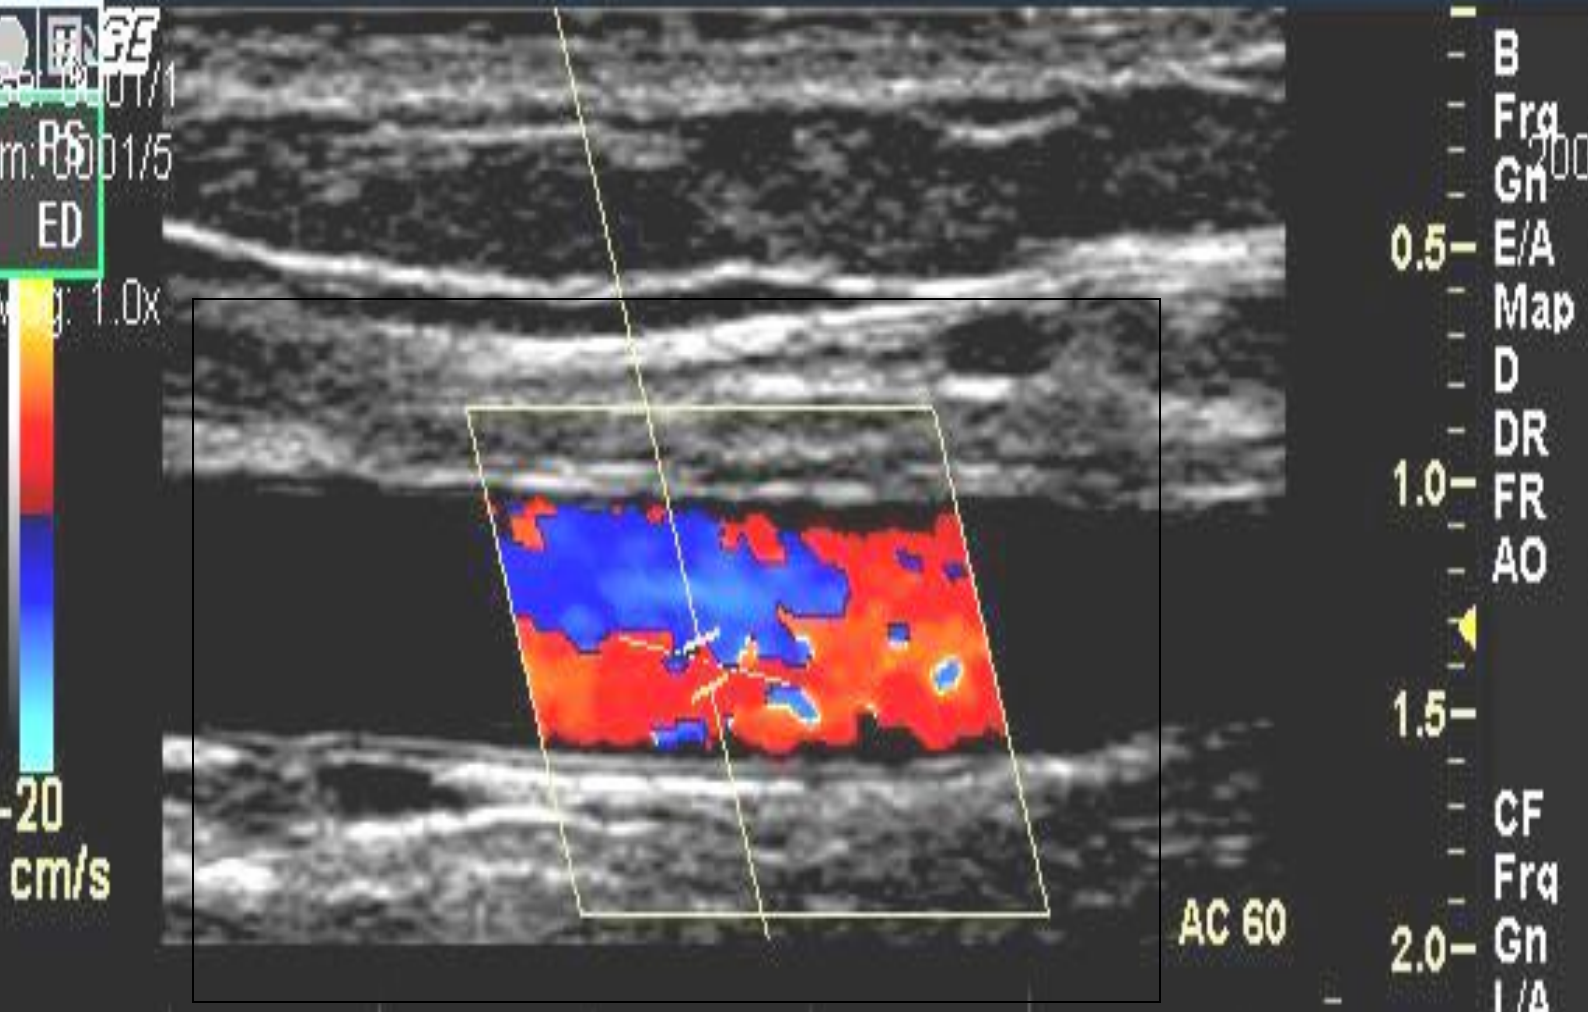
Typical brachial artery ultrasound image for FMD assessment.
